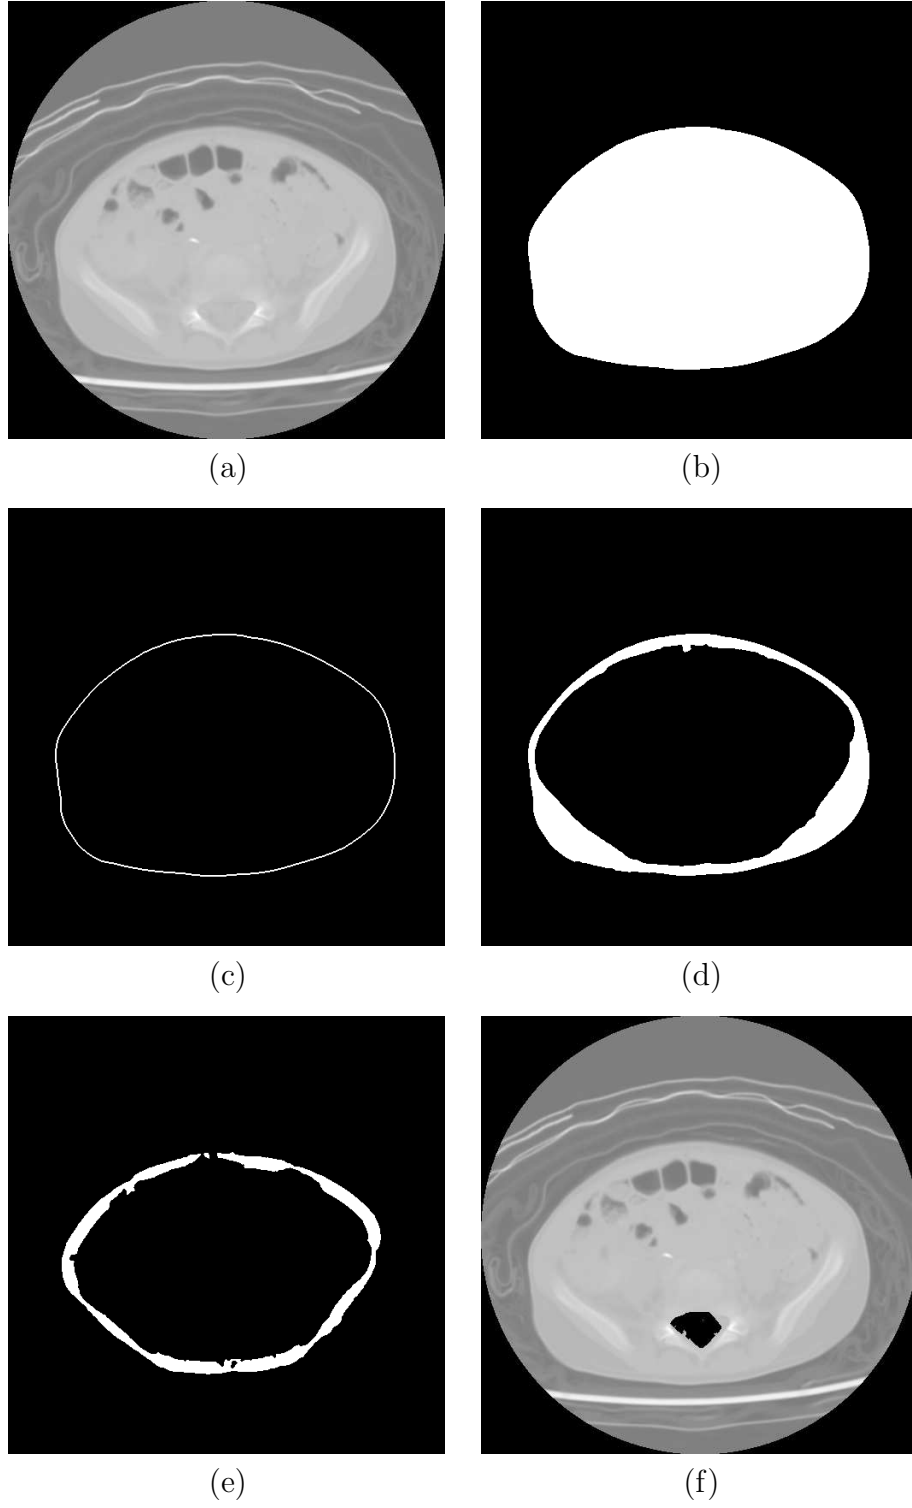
(a) A 512×512 CT slice of a patient. Only one cross section is shown from an exam with 75 slices. (b) External air and artifacts (shown in black). (c) The peripheral skin. (d) The peripheral fat region. (e) The peripheral muscle region. (f) The spinal canal region detected and removed.
